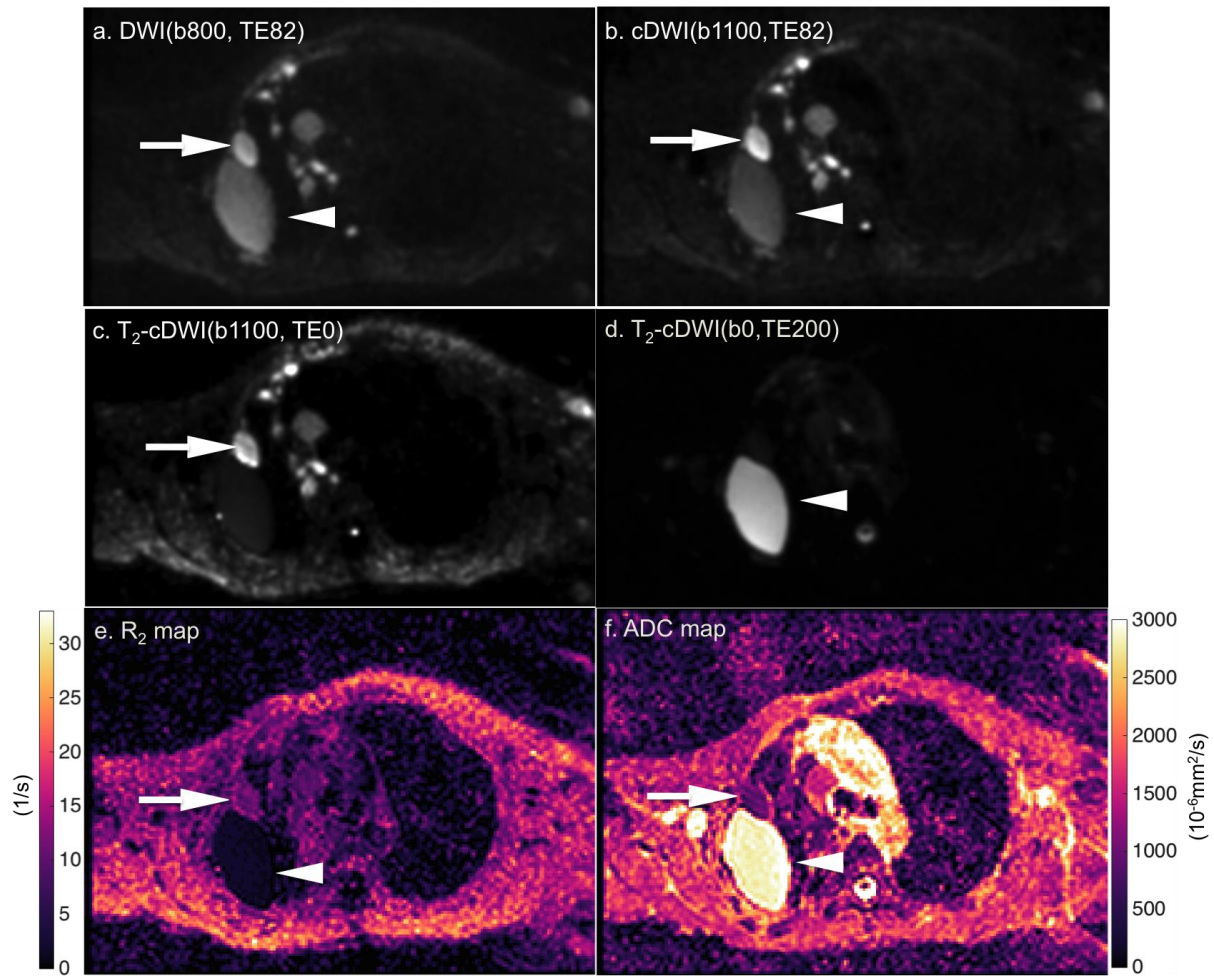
Axial DW MR images of a 62-year-old man with mesothelioma in the right lung for (a) acquired b-values of 800 s/mm<sup>2</sup> at TE of 82 ms, (b) computed b-value of 1100 s/mm<sup>2</sup> at TE of 82 ms, (c) T<sub>2</sub>-adjusted computed b-value of 1100 s/mm<sup>2</sup>, TE of 0 ms, and (d) T<sub>2</sub>-adjusted computed b-value of 0 s/mm<sup>2</sup> TE of 200 ms. (e) R<sub>2</sub> map and (f) ADC map generated from all acquired images. The solid tumour (arrow) and pleural effusion (arrowhead) both show hyperintense signal on the acquired high-b-value DW image due to T<sub>2</sub> shine-through. Pleural effusions are still misinterpreted with solid disease even using a higher b-value in cDWI. By bringing the TE down to zero ms on T<sub>2</sub>-cDWI, pleural effusions are suppressed very well and the solid tumour can be easily segmented out. In
